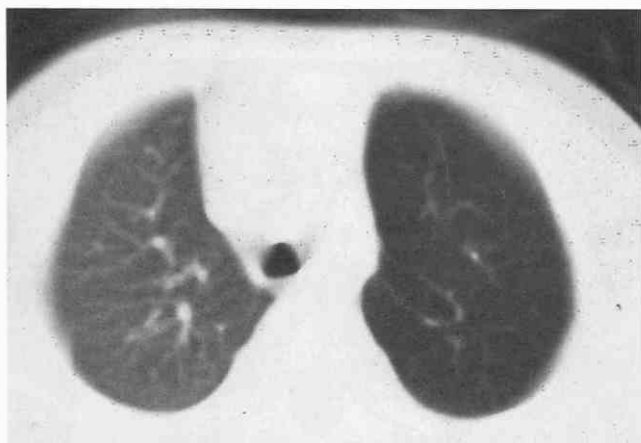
Congenital lobar emphysema in a 23-month-old girl. CT scan shows asymmetrical low attenuation within the left upper lobe. The pulmonary vessels are attenuated compared with those on the right, and the spaces between the vessels are greater on the left than those on the right.
